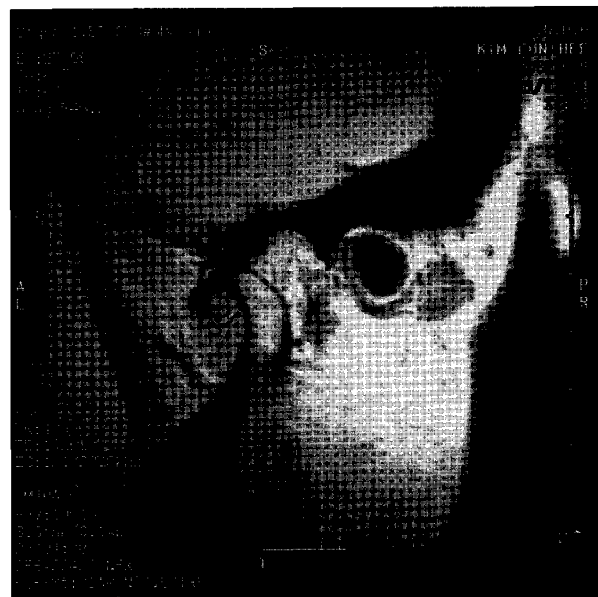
MRI analysis – ADD without reduction (left : closed state, right : open stste).
